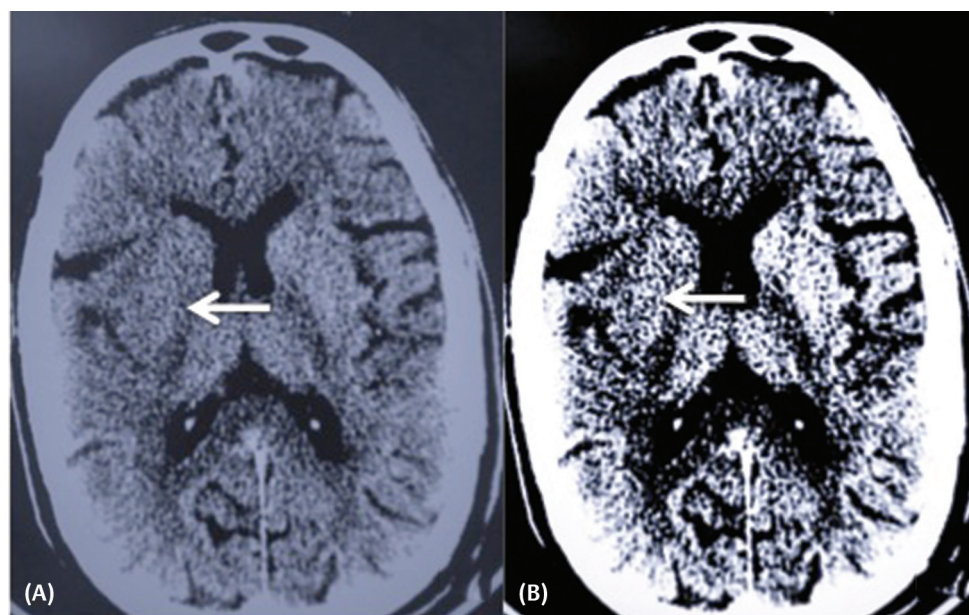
Axial noncontrast computed tomography (CT) brain section at standard brain window (A) and narrow window width setting (B) with arrow indicating increased resolution of lentiform hypodensity in the latter settings.
